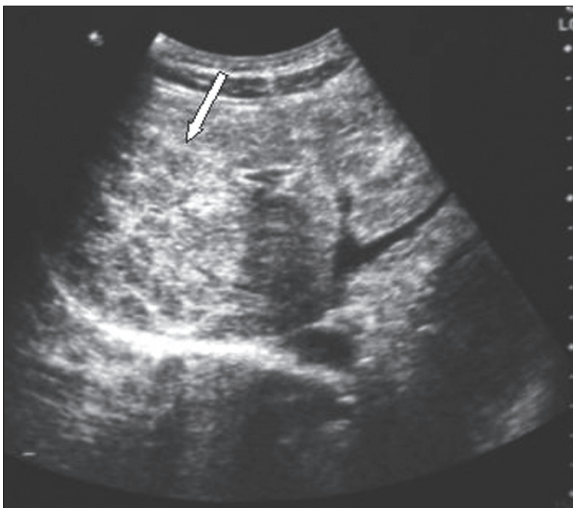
Case 1. Ultrasound of liver: echogenic septa (arrow) outlining normal areas of liver parenchyma.
